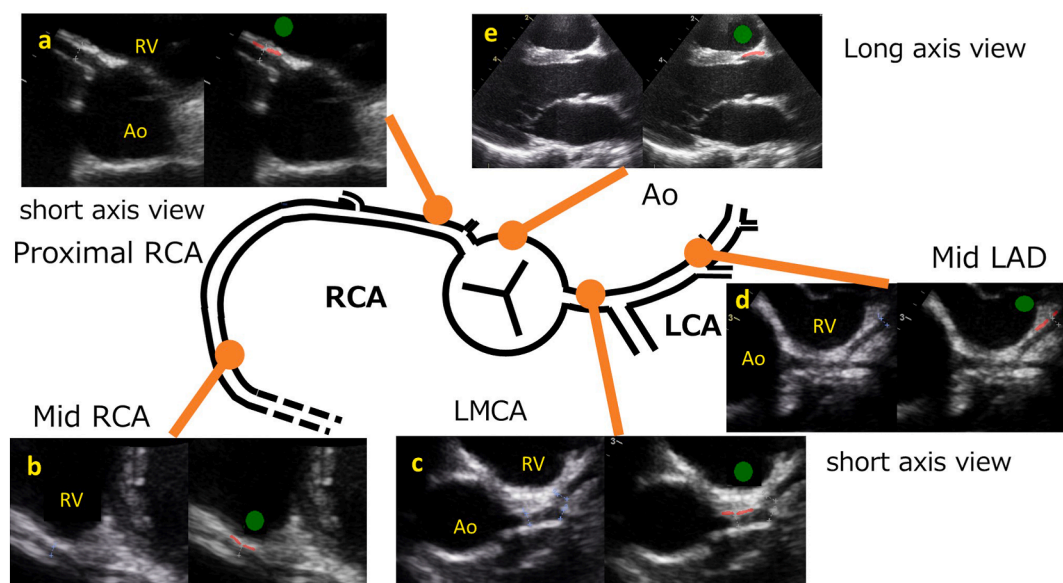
Method of measurement of arterial wall brightness in echocardiographic images. (A) Proximal RCA, (B) mid RCA, (C) LMCA, (D) mid LAD in the short-axis view, and (E) right coronary sinus of the aorta in the long-axis view. Red lines, approximately 5 to 10 mm in length, were applied to the anterior wall of the coronary artery (thoracic side only) and the right coronary cusp of the aorta. The markings were placed in regions excluding the measured areas present in the original image. To perform correction, the intracardiac blood pool located on the thoracic side within the region of interest was marked with a green circle, which served as the reference background value. Ao, Aortic valve; LA, left atrium; LCA, left coronary artery; RV, right ventricle.
